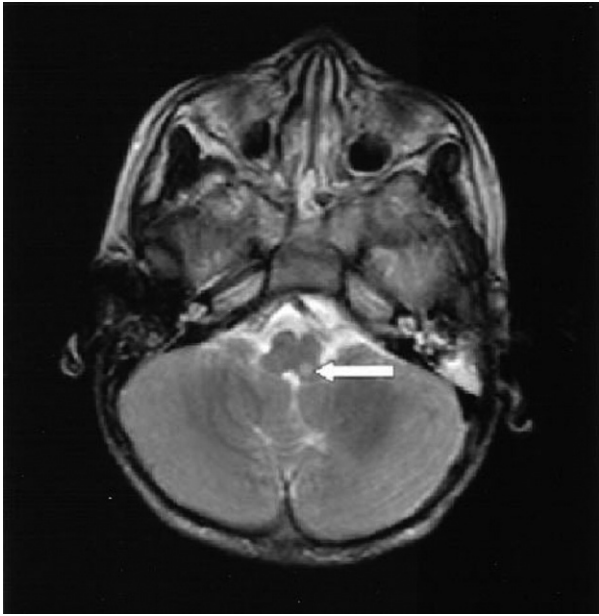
MR image with white arrow demonstrating stroke in the left medulla.
